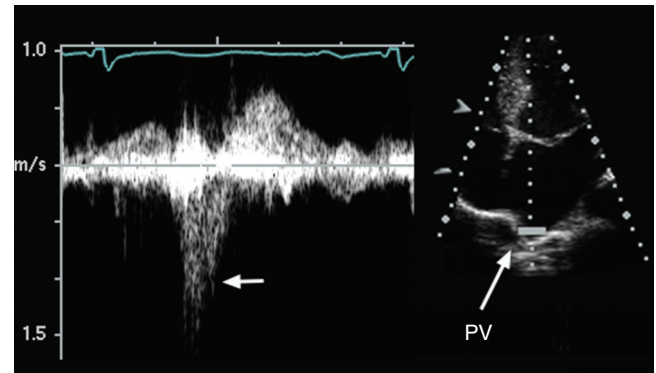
■ Pulmonary vein tracing in a patient with significant mitral regurgitation. The Doppler signal is positioned in the right upper pulmonary vein (PV; right). Spectral Doppler tracing shows mid-late systolic flow reversal directed away from the transducer (arrow, left).
